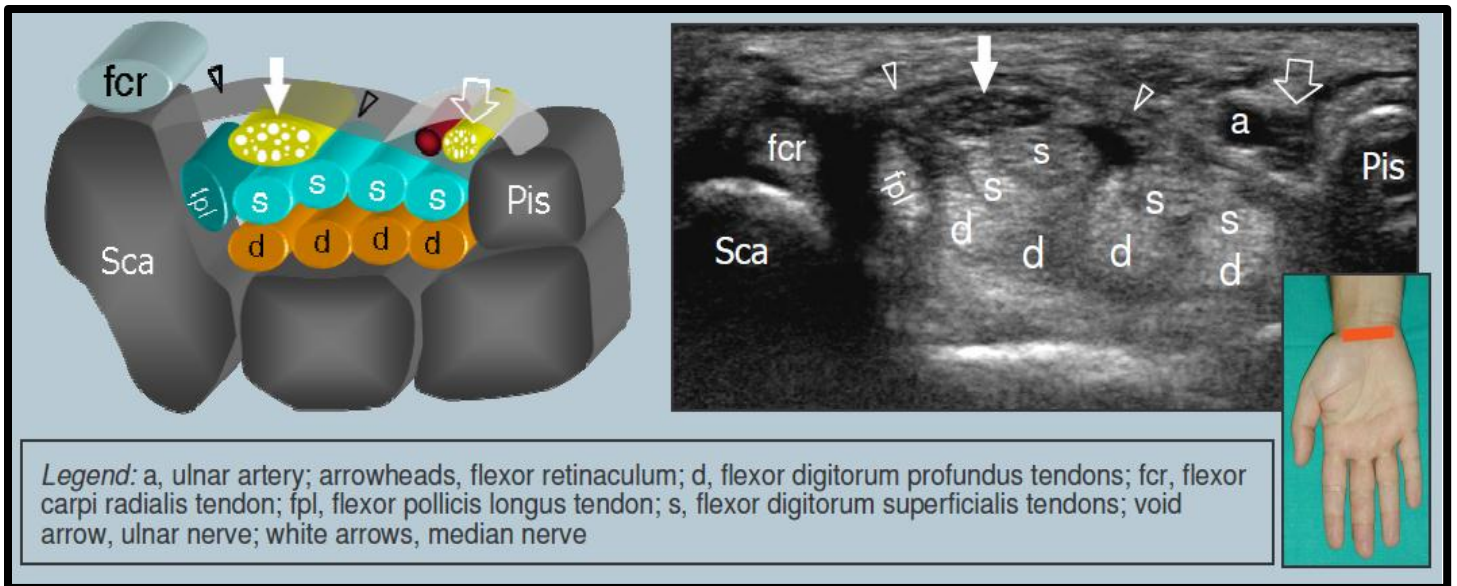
Carpal Tunnel Anatomy at the Level of the Pisiform (European Society of Musculoskeletal Radiology. Musculoskeletal Ultrasound Technical Guidelines, <http://www.essr.org/html/img/pool/wrist.pdf>)
